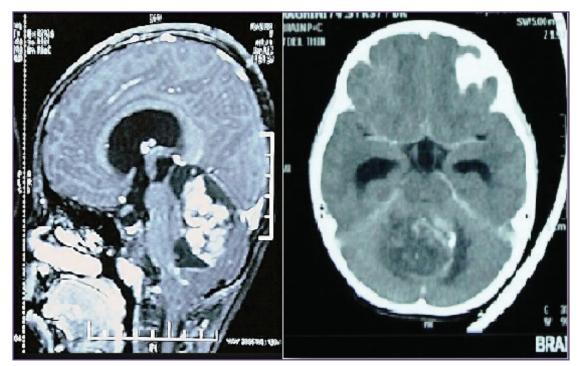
MRI brain showing a large a high density, contrast-enhancing lesion in posterior fossa arising from the cerebellar vermis measuring 4.1 X 3.5 X 3 cms
